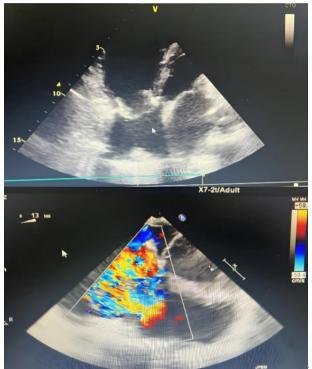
The image shows the patient's transesophageal echocardiogram on the sixth day of hospitalization.
